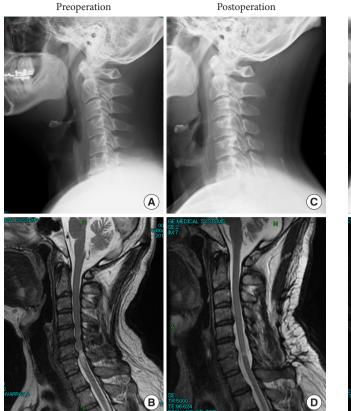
Case presentation of a 37-year-old man. (A) The preoperative C2–7 angle was -7.4° in an x-ray image. (B) Sagittal T2-weighted magnetic resonance imaging revealed cervical canal stenosis at multiple intervertebral levels. (C) After laminoplasty, the C2–7 angles improved to a lordotic angle of 7.6°. (D) Appropriate spinal cord decompression was observed postoperatively.
